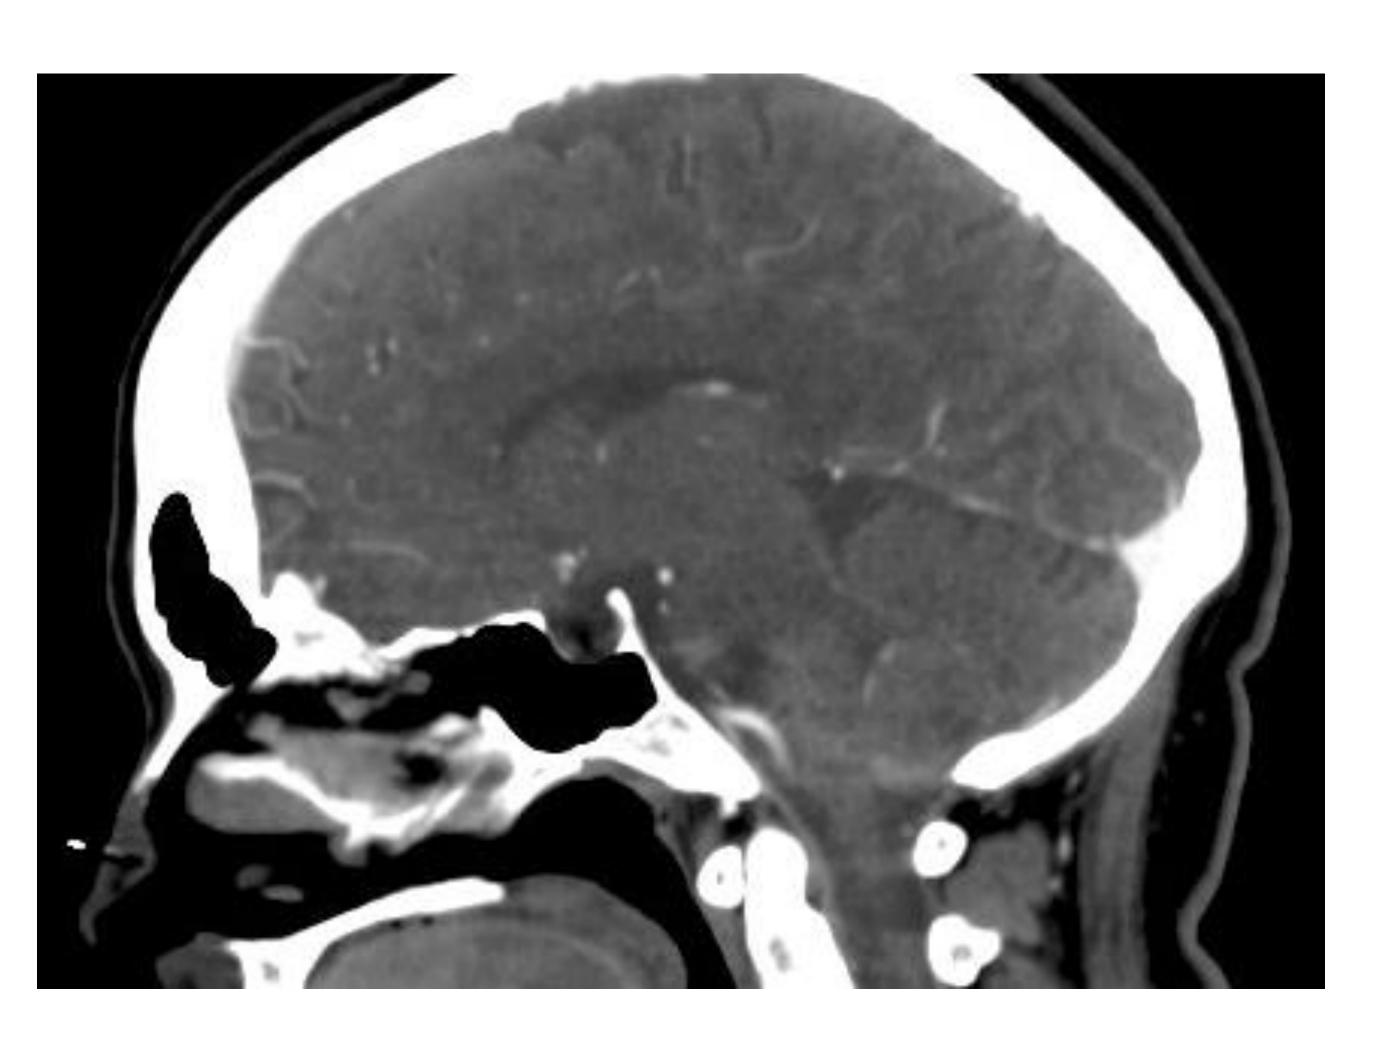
Empty Sella visualized on CT scan
